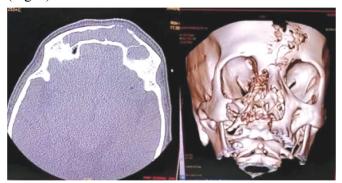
CT scan and 3D reconstruction showing erosion of outer table of frontal sinus
